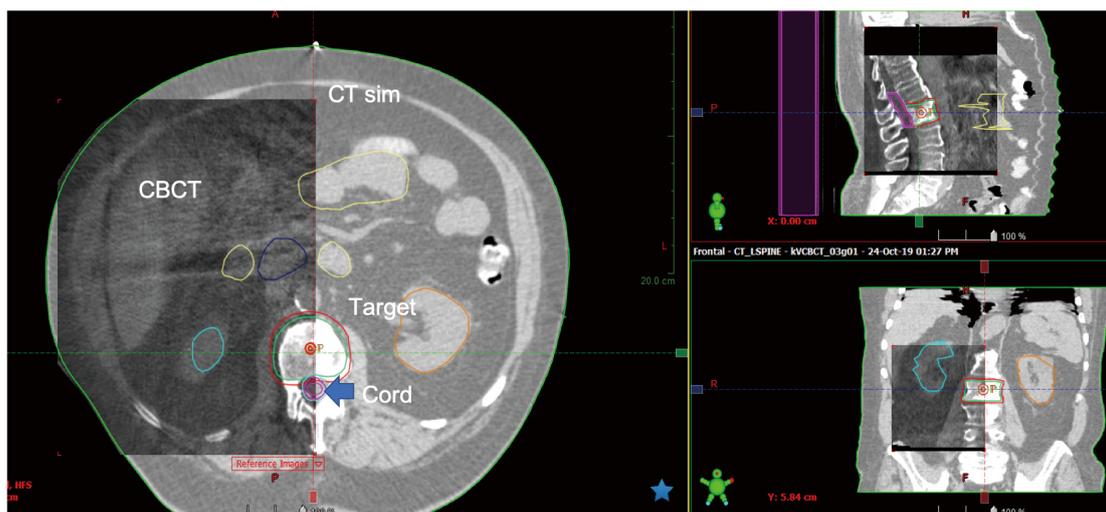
Example of treatment verification using CBCT: the position of the target and OARs is verified in all planes. OAR, organs at risk.
